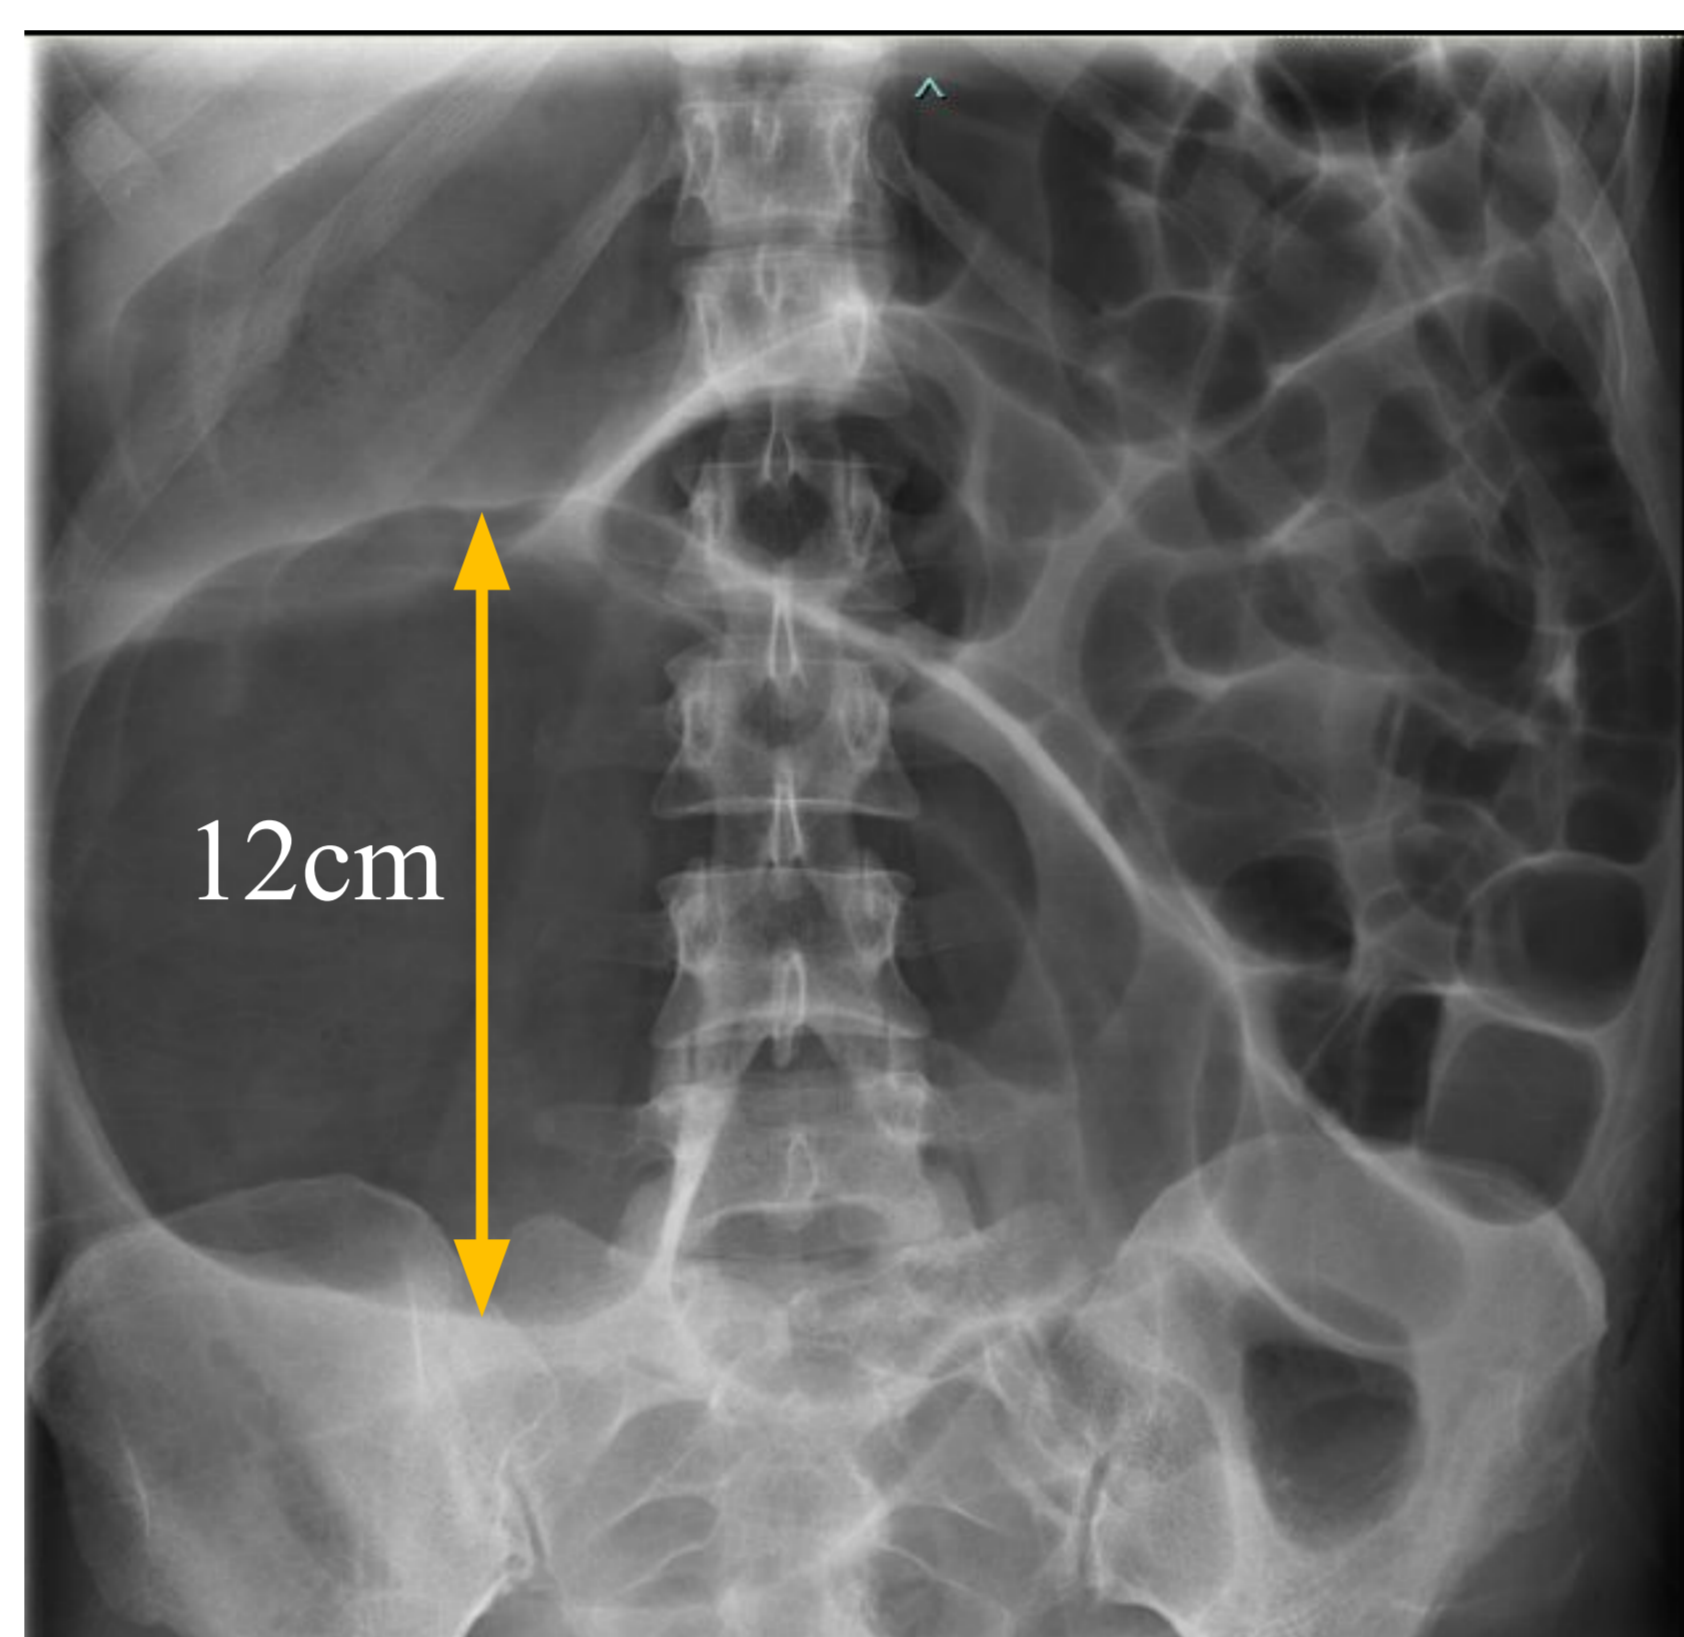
Abdominal x-ray
